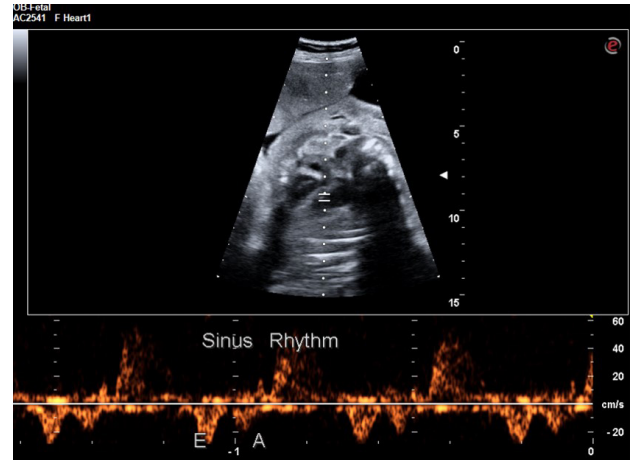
Mitral inflow and aortic outflow view. Mitral spectral doppler showing E wave and A wave followed by aortic outflow doppler
